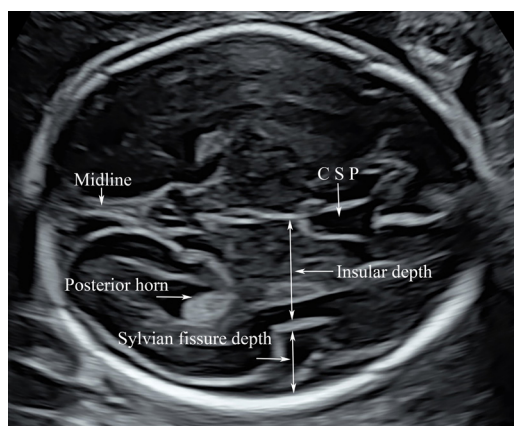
Ultrasound imaging for fetal brain measurements: measurements of the depth of insula (double-headed arrow) and sylvian fissure (double-headed arrow) in the trans-ventricular view at 25 gestational weeks. CSP, cavum septi pellucidum.
